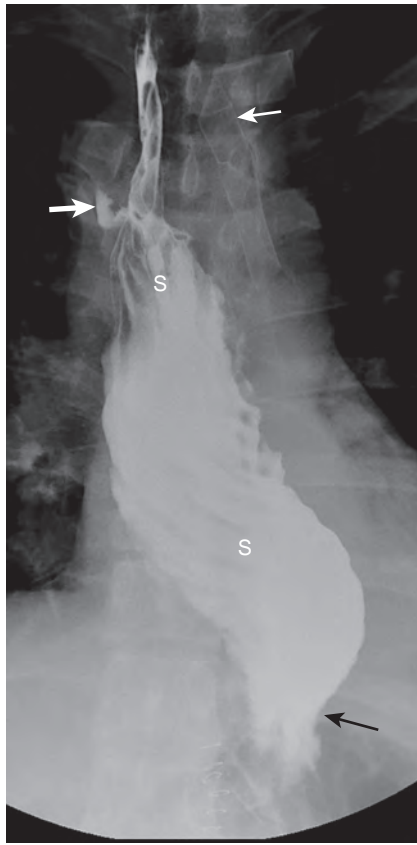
Transthoracic esophagogastrectomy. The stomach (S) has been pulled into the right hemithorax. There is a small contained leak (thick white arrow) at the esophagogastric anastomosis. There is no obstruction as the stomach passes through the diaphragm (black arrow). A mediastinal drain (thin white arrow) is present.
